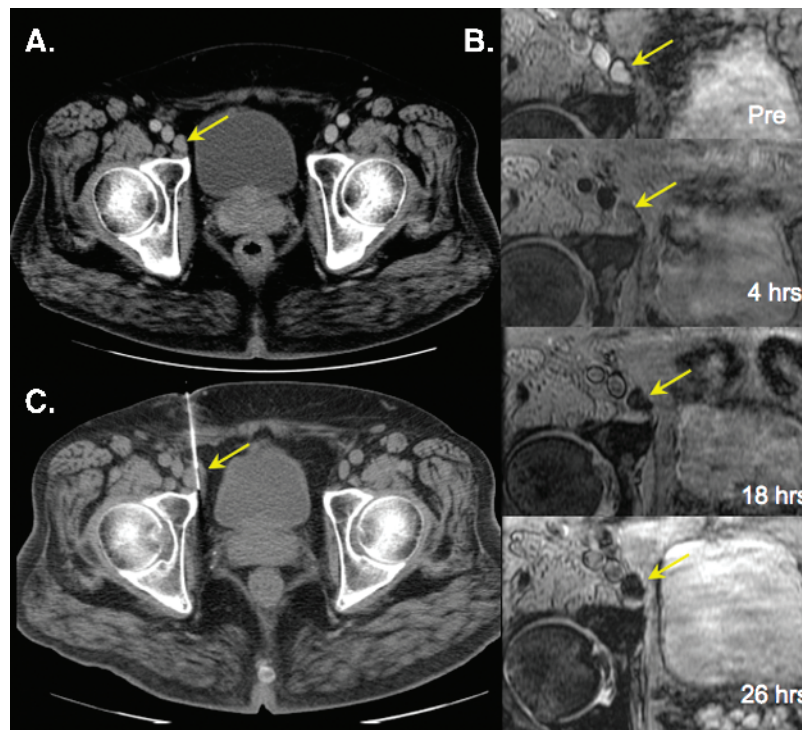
Benign right external iliac node. (A) Axial contrast-enhanced computed tomographic (CT) image shows an enlarged right external iliac node. (B) Sequential images show progressive loss of signal following ferumoxytol administration. (C) CT-guided biopsy showing biopsy needle within the enlarged lymph node.
